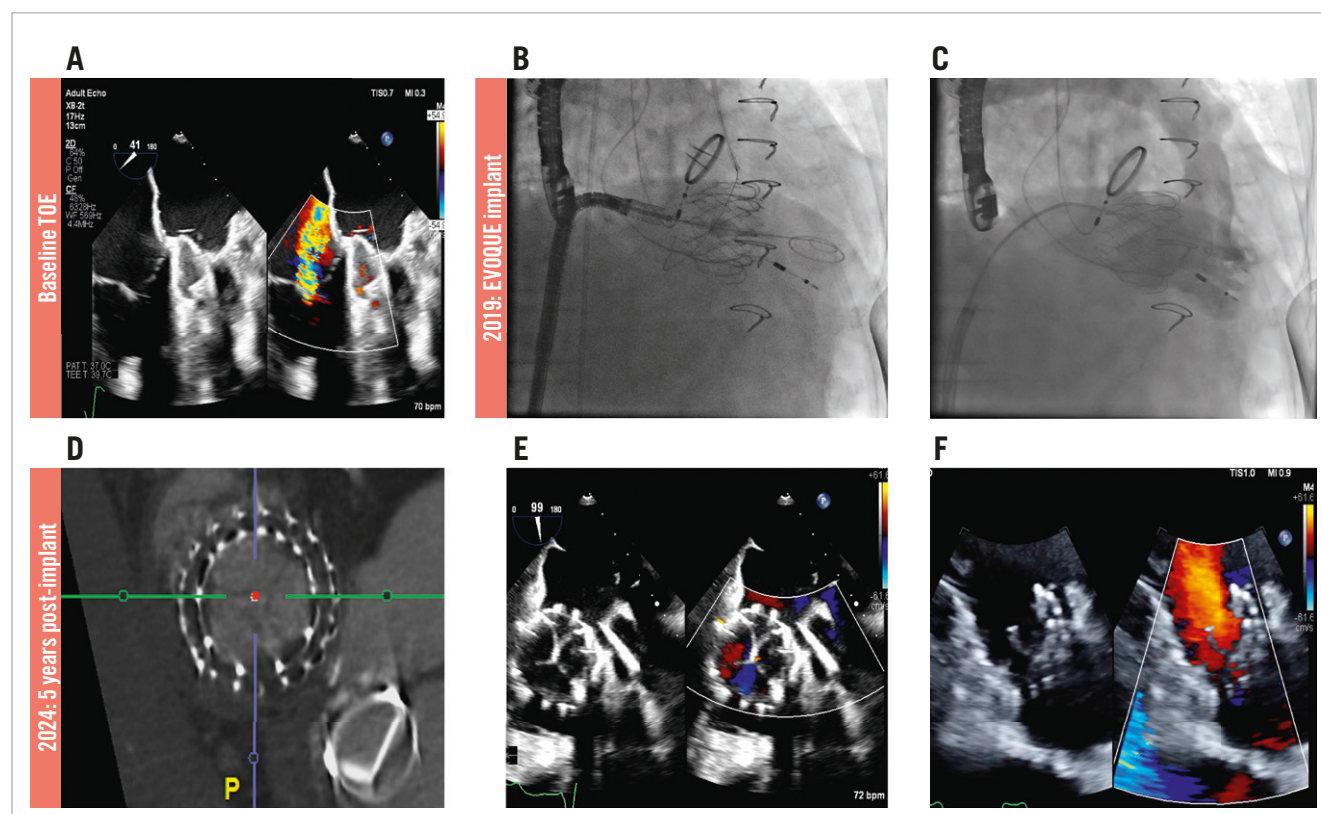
Five-year follow-up of transcatheter tricuspid valve replacement with the EVOQUE valve. A) Preprocedural transoesophageal echocardiogram shows severe tricuspid regurgitation. B) Fluoroscopy of the EVOQUE valve implant shows the deployed valve. C) Right ventricular angiogram via a pigtail catheter immediately post-implant shows minimal residual TR. D) CT 5 years post-implant shows no evidence of structural valve deterioration. E,F) Transoesophageal and transthoracic echocardiogram images 5 years post-TTTR shows minimal residual TR. CT: computed tomography; TR: tricuspid regurgitation; TTTR: transcatheter tricuspid valve replacement
